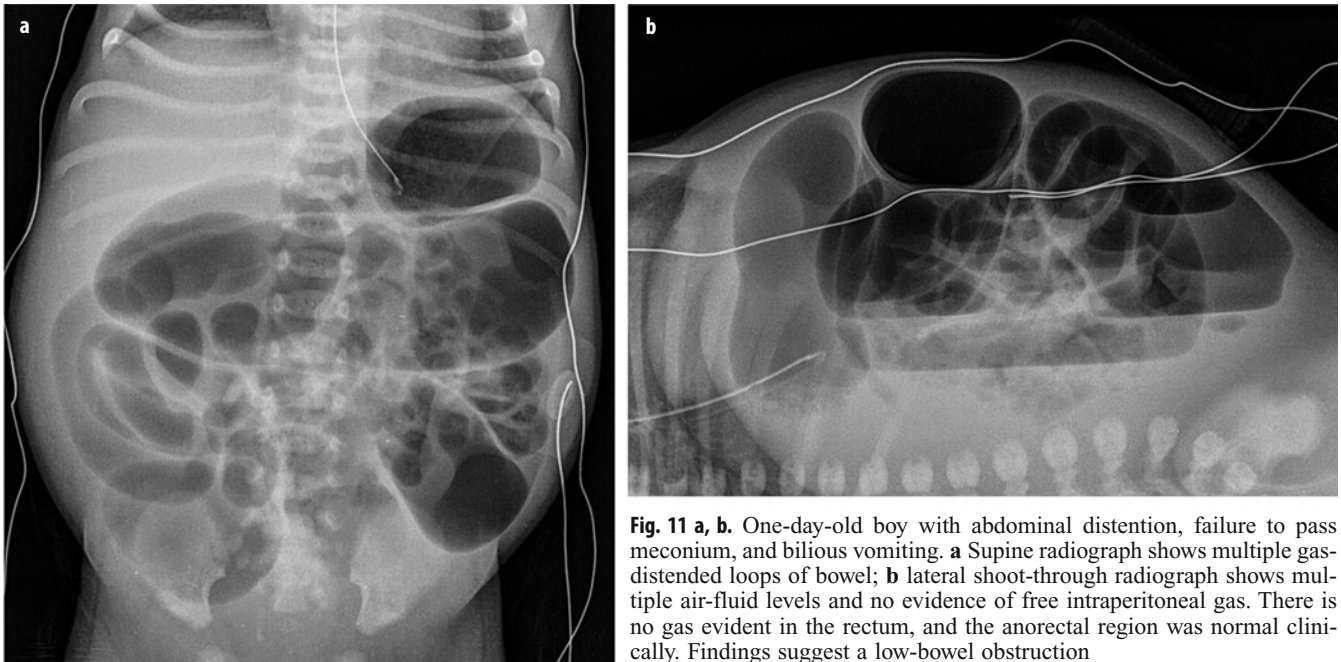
a, b. One-day-old boy with abdominal distention, failure to pass meconium, and bilious vomiting. a Supine radiograph shows multiple gas-distended loops of bowel; b lateral shoot-through radiograph shows multiple air-fluid levels and no evidence of free intraperitoneal gas. There is no gas evident in the rectum, and the anorectal region was normal clinically. Findings suggest a low-bowel obstruction
